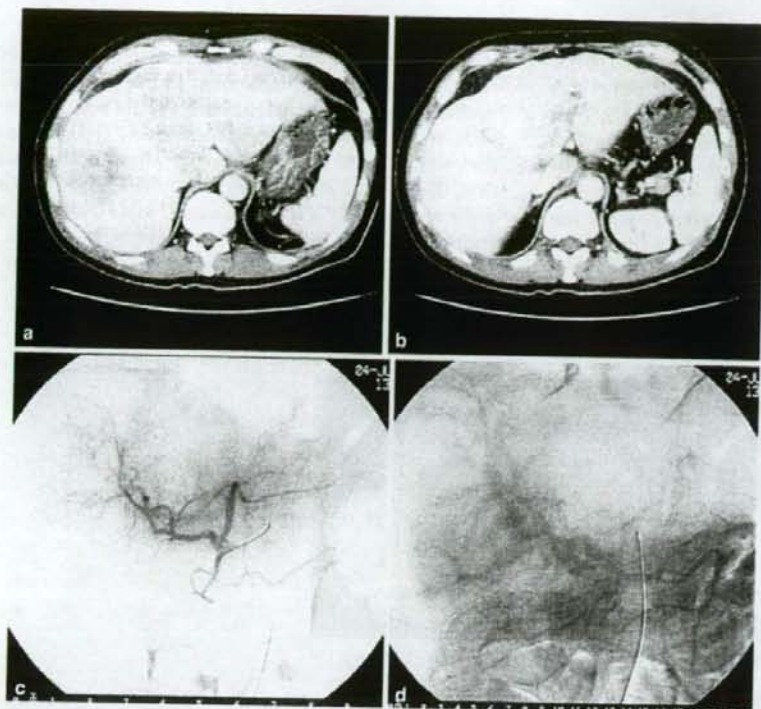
a, b Abdominal computed tomography. c, d Hepatic arteriography and portography. a Abdominal computed tomography showed the main tumor infiltrating in the left and caudate lobes and an intrahepatic metastasis in the right lobe. b The left branch of the portal vein was filled with tumor thrombus. c Angiography revealed multiple lesions in the right lobe of the liver. d Portography showed a portal vein tumor thrombus, and that growth had begun in the left lobe and spread into the right branch via the main trunk of the portal vein
